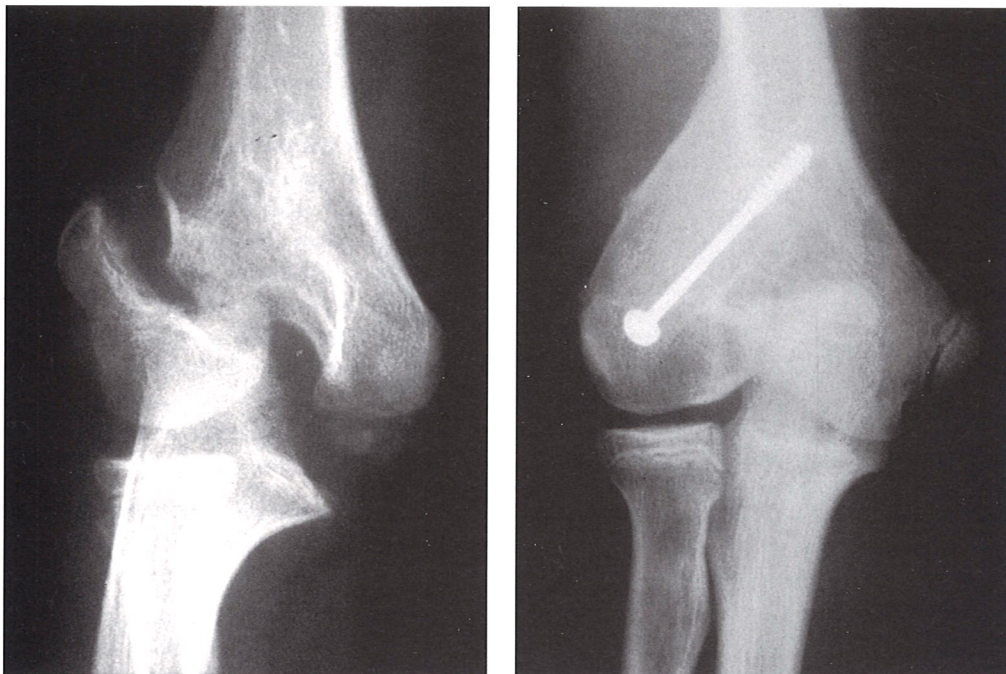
Left, Nonunion of the lateral condyle in a 7-year-old boy. At 5 years of age, he was treated with a sling for what was believed to be an "elbow sprain". Note the large metaphyseal fragment, open physis, and 1-cm joint displacement. Right, Post-operative radiograph showing late reconstruction, screw fixation, bone grafting.
